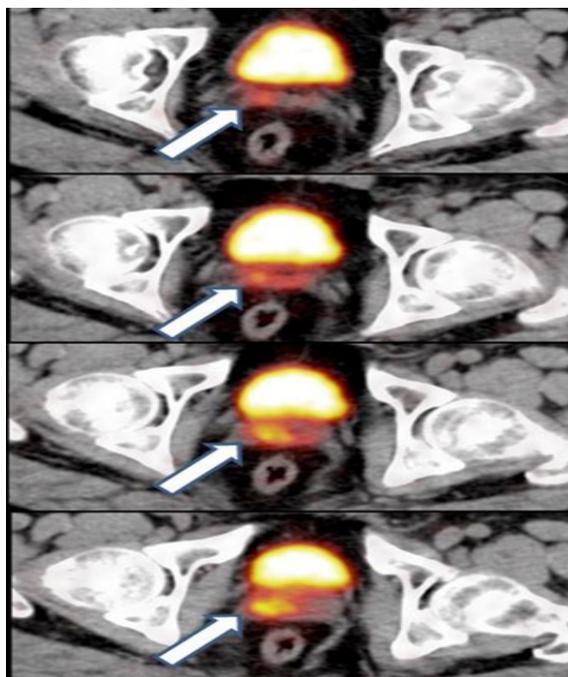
The PSMA PET/CT image of patient with prostate cancer showing seminal vesicle involvement. The white arrows show the seminal vesicle involvement on the PSMA-PET CT scan.
